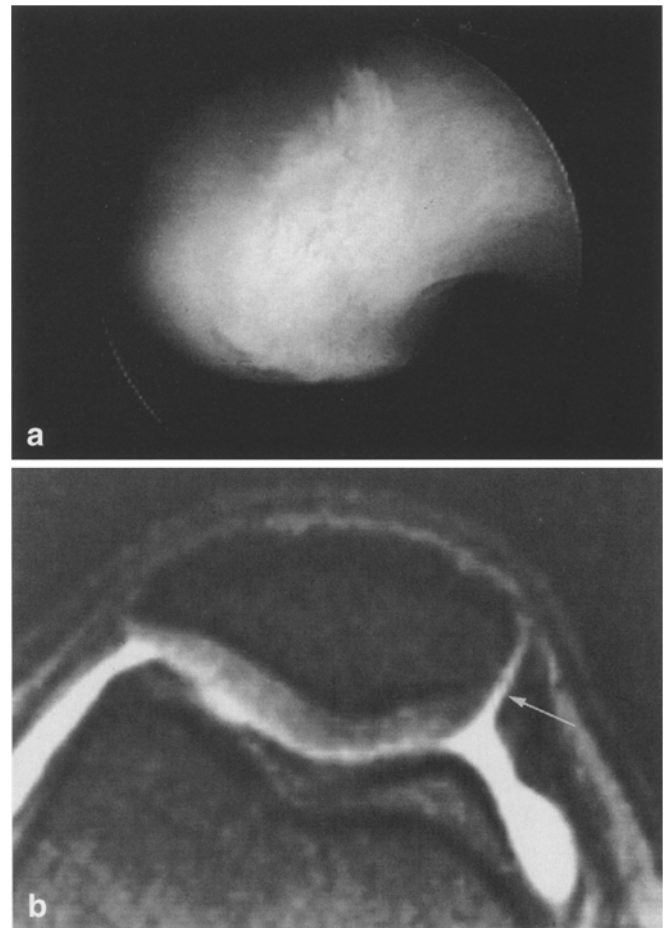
a Arthroscopic image showing the sharp end of the medial facet of the patella that can be mistaken for a lesion on MRI. b T2 GRE MRI in the transverse plane showing the “step pitfall” (arrow)
